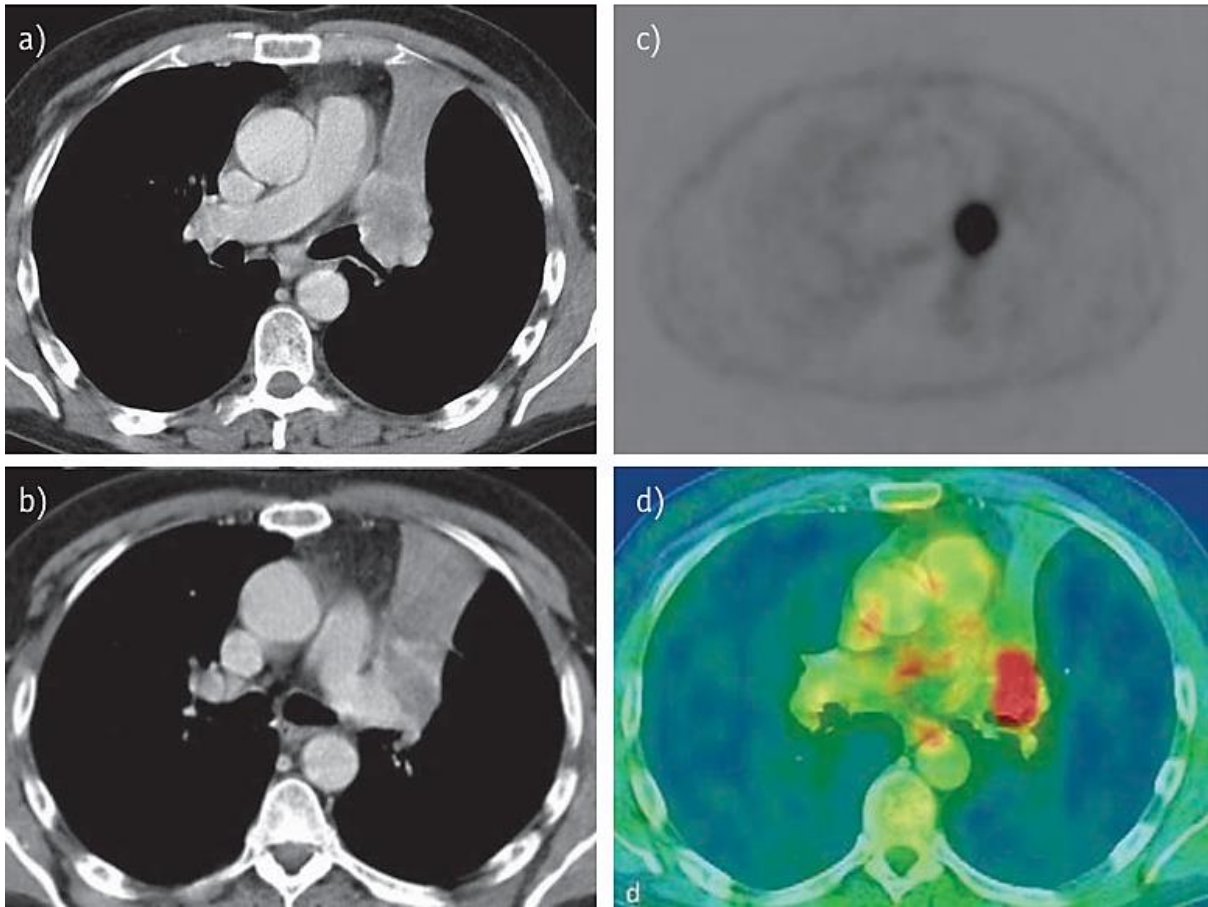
Integrated PET/CT of a central left lung tumor. (a–b) Axial CT images show a central tumor with associated retro-obstructive atelectasis. (c) PET demonstrates FDG uptake within the tumor but not within the atelectatic lung, enabling accurate tumor localization on fused PET/CT images. Adapted from (de Wever et al., 2011)
